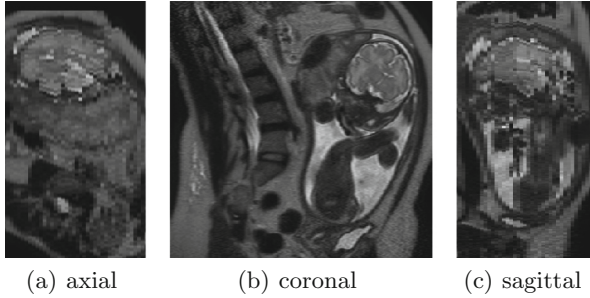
Three orthogonal cutting planes through a stack of fetal MRI images. The quality of the in-plane (coronal) slices is not affected by motion, however, there are inter-slice artifacts appear in the out-of-plane views (axial and sagittal).
